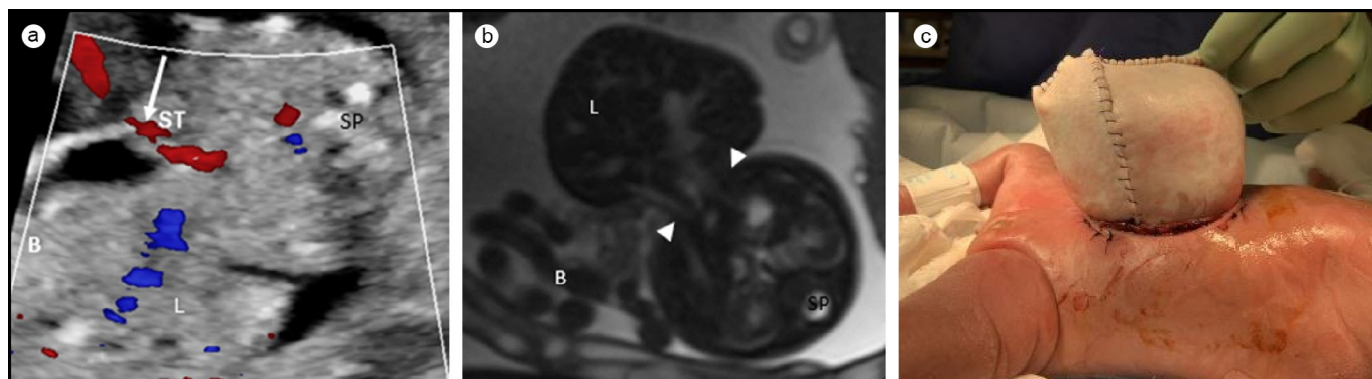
(a) Prenatal ultrasound imaging. Axial image at 20 weeks shows color flow in the umbilical cord to the left of the defect (arrow), as well as a portion of extracorporeal stomach (ST), bowel (B), and liver (L); the spine (SP) is labeled for orientation. (b) Fetal magnetic resonance imaging axial T2 HASTE at 25 weeks' gestation. Ventral abdominal wall defect (arrowheads) through which the majority of the liver (L) has herniated in addition to small and large bowel (B). The spine (SP) is labeled for orientation. (c) Two pieces of 8 × 16 cm Strattice mesh were trimmed to fit and circumferentially sewn to the abdominal wall.
